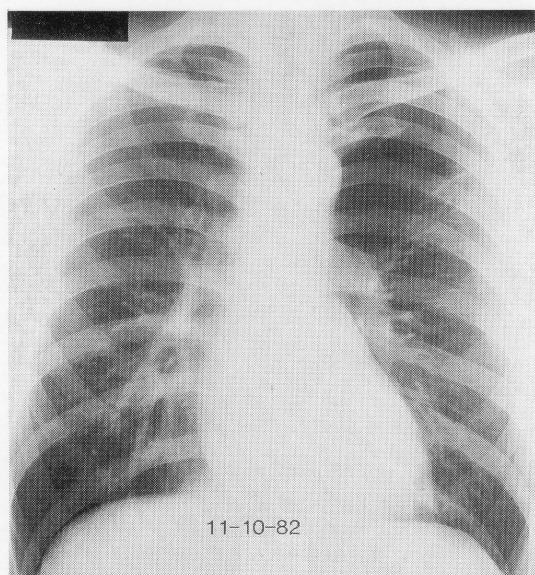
Preoperative chest radiograph (11-10-82). Note bilateral apical bullae.
